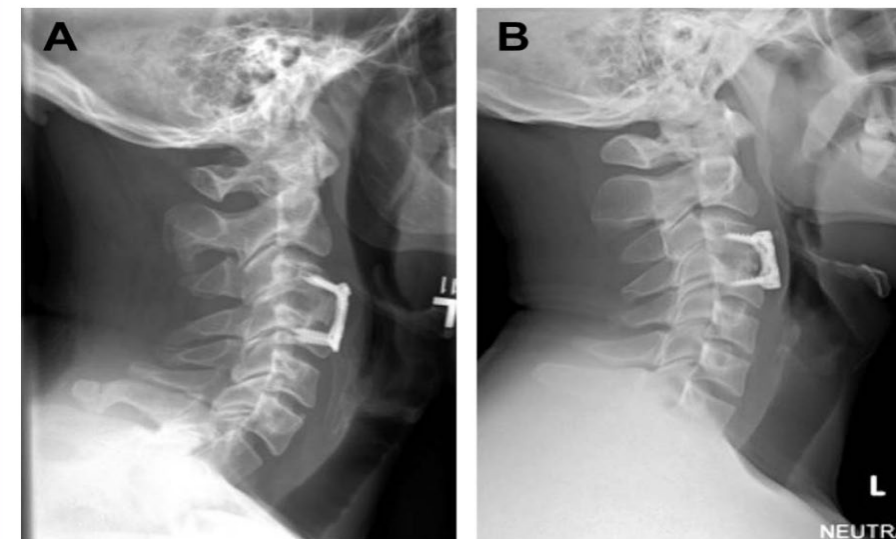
Lateral C-spine radiographs of 2 patients (A and B) demonstrating solid arthrodesis at the operative level 6 months after surgery.
